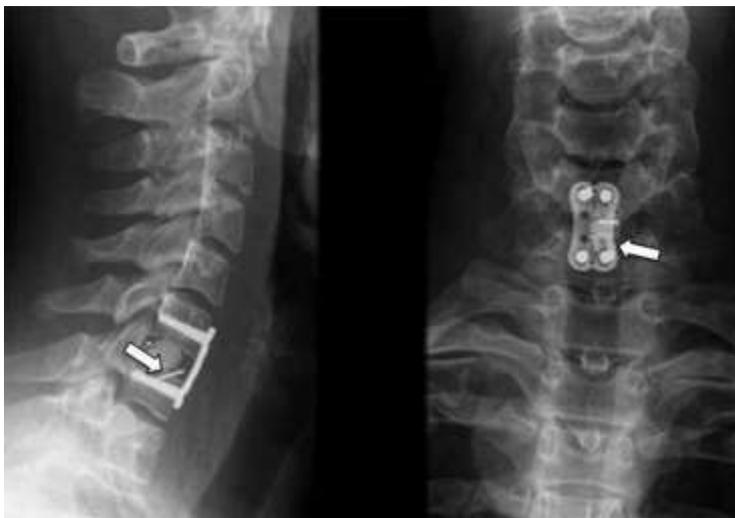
“Lateral (a) and anterior (b) X-rays showing anterior cervical fusion by a PEEK cage filled with synthetic bone graft combined with an anchoring clip (arrows) and an anterior locking plate”⁴
